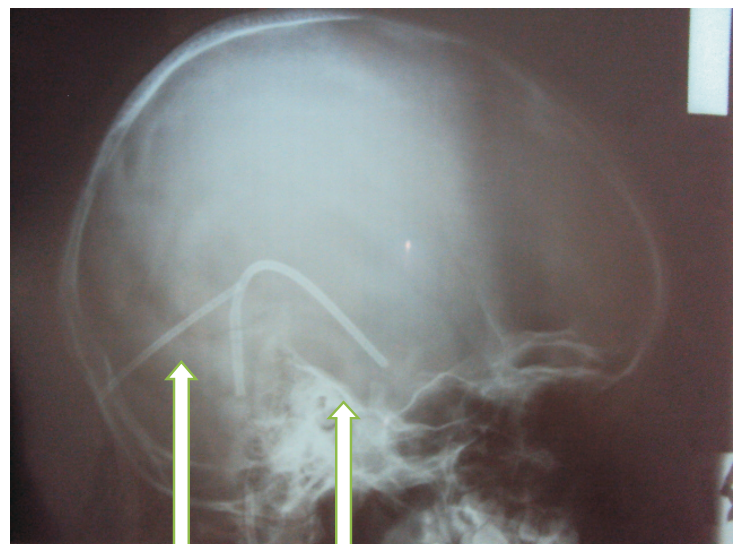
Brain CT Scan (Reconstruction)
